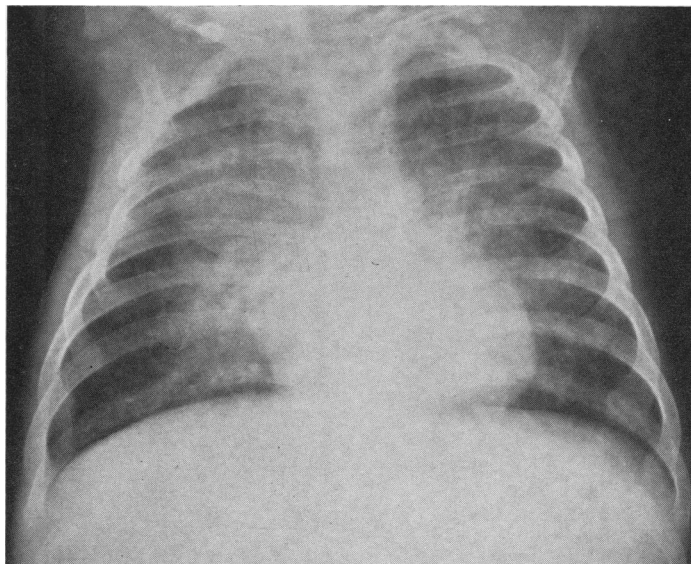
Radiograph of chest one month before death.
